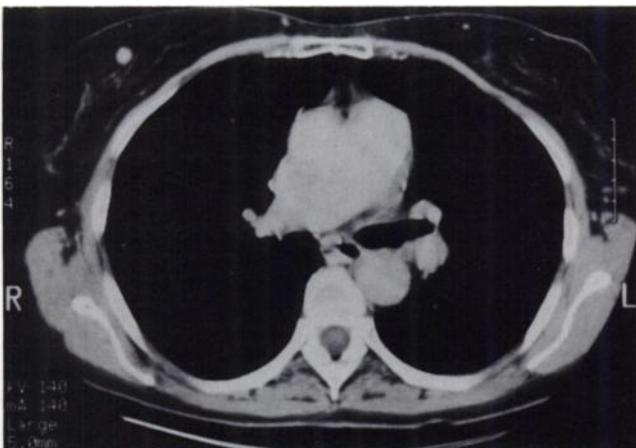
A single slice of a computed tomogram showing breast tissue and a high density, well circumscribed lesion present in the right breast, separate from the chest wall.
